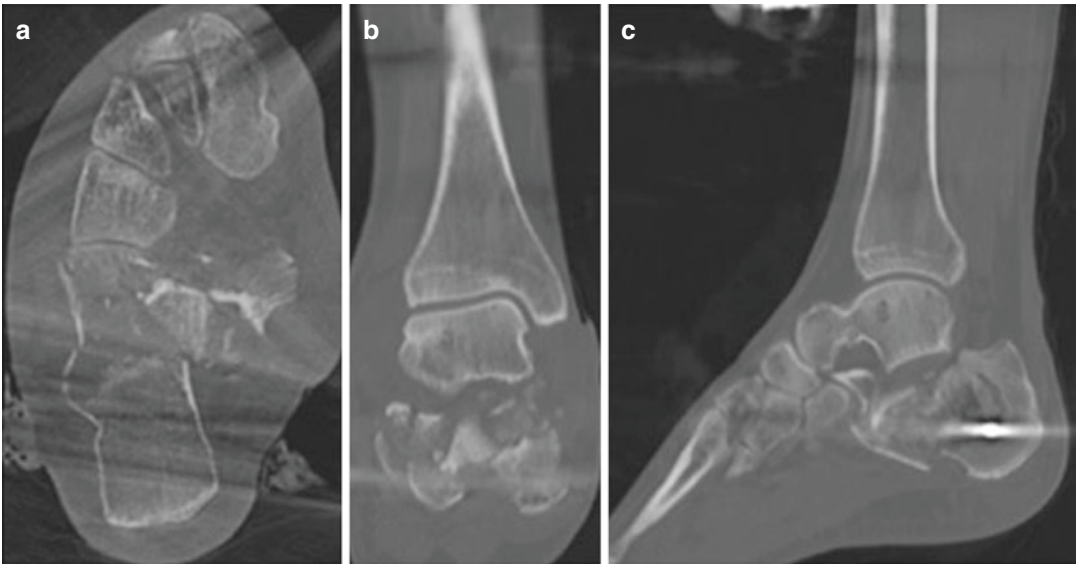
(a) Axial, (b) coronal, and (c) sagittal plane computed tomography images demonstrating significant articular comminution and depression
